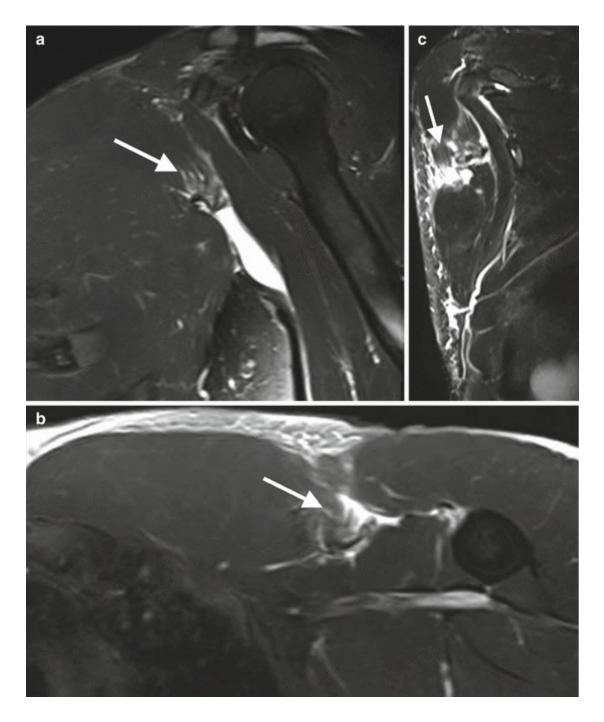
A 23-year-old-man with complete pectoralis major tear at humeral insertion after bench press exercise. Coronal fat-suppressed T2-weighted MRI shows complete tendon retraction (*arrow*, a) and a fluid collection. Axial (b) and sagittal (c) fat-suppressed T2-weighted MRIs show complete discontinuity at humeral insertion (*arrow*)
